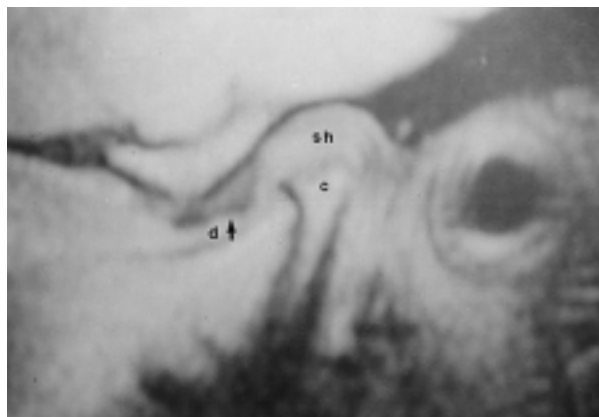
MRI sagittal view of the left TMJ of case 1 shows an anteriorly displaced articular disk (*d*) and an increased thickness of amorphous tissue (synovial hyperplasia) (*sh*) overlying the condyle (*c*). Note the diminutive size of the condyle, with some anterior beaking and with loss of definition of the cortical bone over the head of the condyle.
